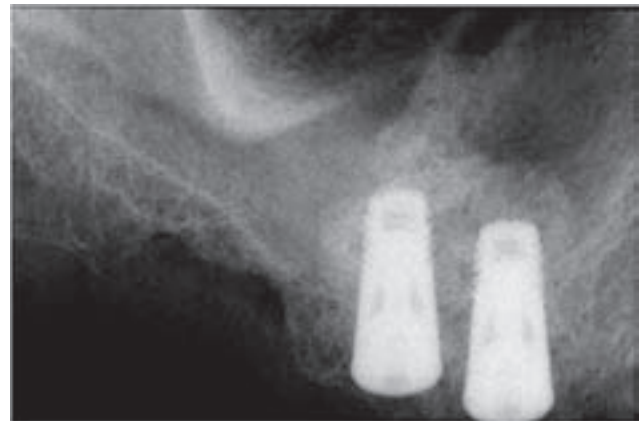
Periapical radiograph suggesting a sinus tear at the maxillary right first molar. The bone graft material is poorly contained, as indicated by the lack of a dome shape to the sinus lift. (Courtesy of Michael Toffler.)
